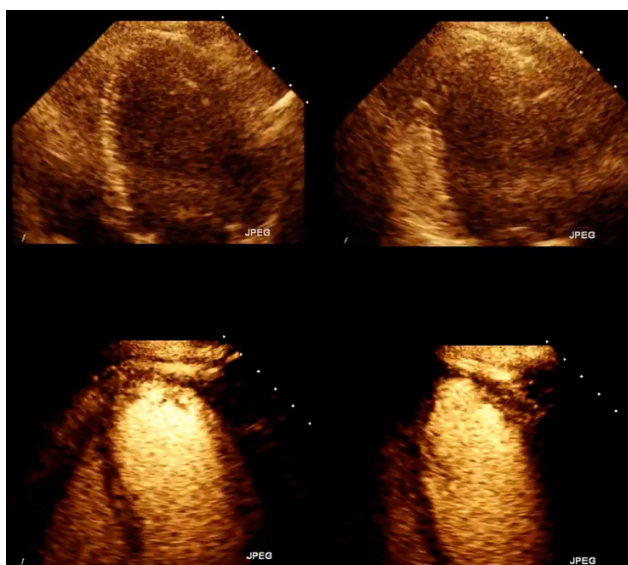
Microbubble enhanced stress echocardiography. Base-line non-enhanced images are recorded in apical 4 and 2 chambers (A,B), demonstrating insufficient delineation of the endocardial borders; With contrast (C,D) the LV contours become clearly visible. Source: personal collection.
